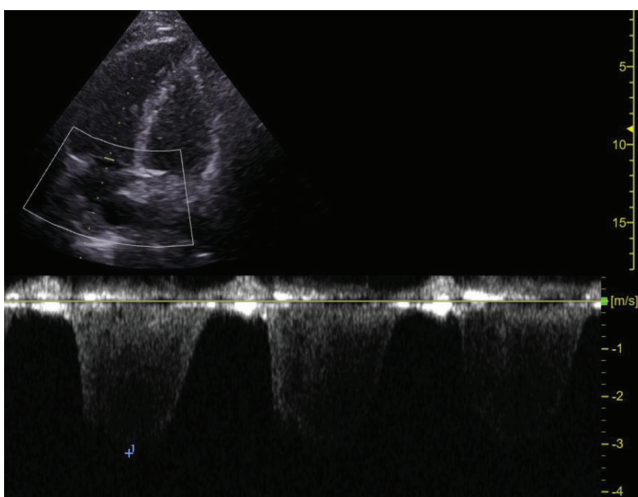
Apical 4 chamber view showing dilated RV and increased RV-to-LV ratio with a peak tricuspid regurgitation envelope maximum velocity (TRVmax) over 3 m/s.
